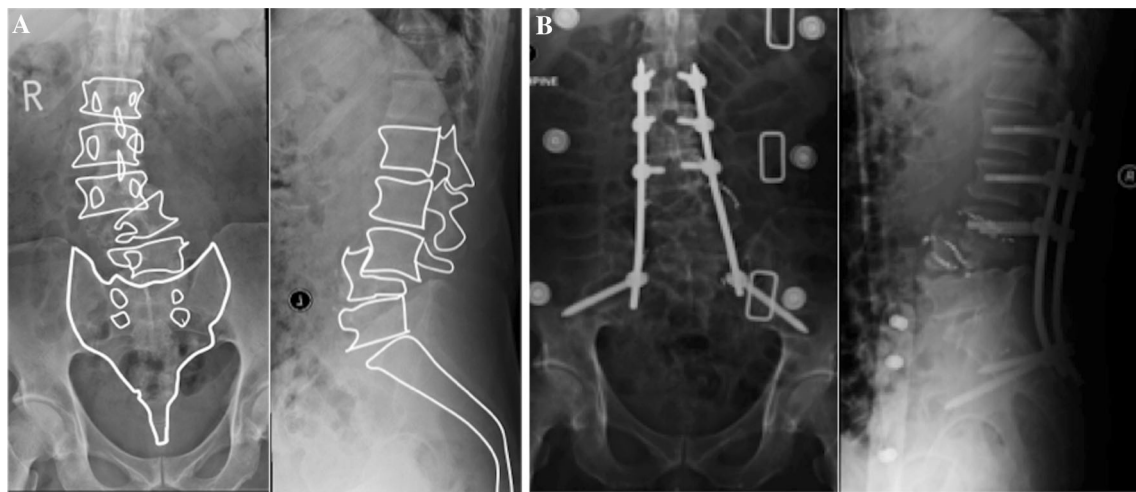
Patient E had metastatic renal cell carcinoma with extensive vertebral involvement result in LSJ deformity (a). Post-op radiographs (b) showing L1, L2 and L3 and bilateral iliac instrumentation
